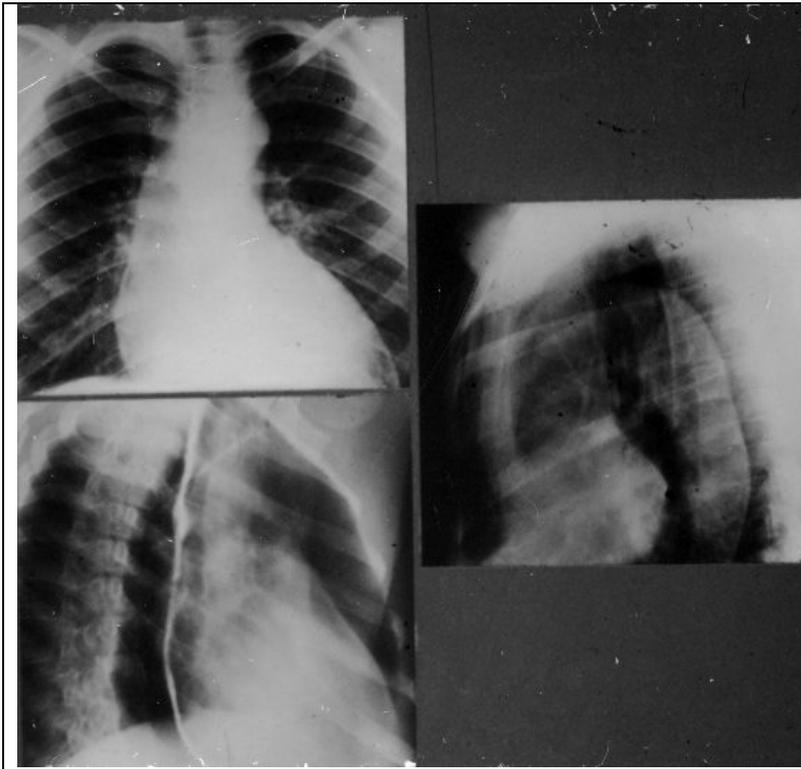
Heart radiographs in a direct, right (first) slanting projection, the left (second) slanting projection. Arches of the ascending aorta and left ventriculus in a direct projection are increased. In the right (first) slanting projection the bottom arch of a forward contour is formed left ventriculus is increased. In the left (second) slanting projection the bottom arch of a back contour is formed left ventriculus which accumulates on a backbone is increased. On a forward contour the ascending part of the aorta is increased, as the angle between an aorta and the right chambers of heart is displaced from top to bottom. Aortic heart disease.
